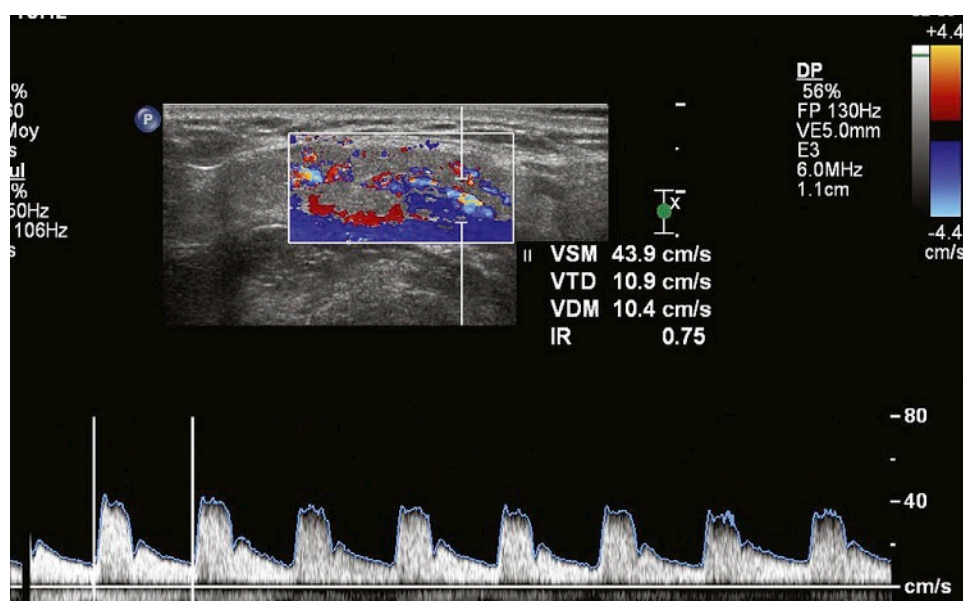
A Doppler waveform is seen for the facial artery in a patient with primary Sjögren's syndrome before lemon stimulation. Notice the systolic peak. There was decreased impedance in the submandibular vessel with a decrease in the resistive index ($RI = 0.75$).
